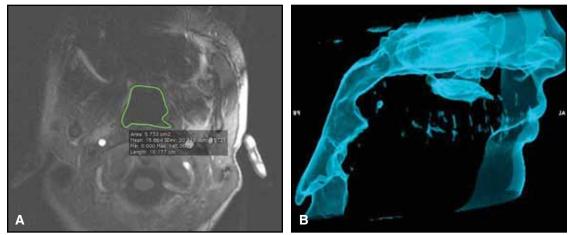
A. Three-dimensional cross-section of patient's airway from MRI, involving no radiation exposure. B. Cone-beam computed tomography (CBCT) scan of airway shape and volume (different patient), requiring 45-70 microSieverts of radiation.
